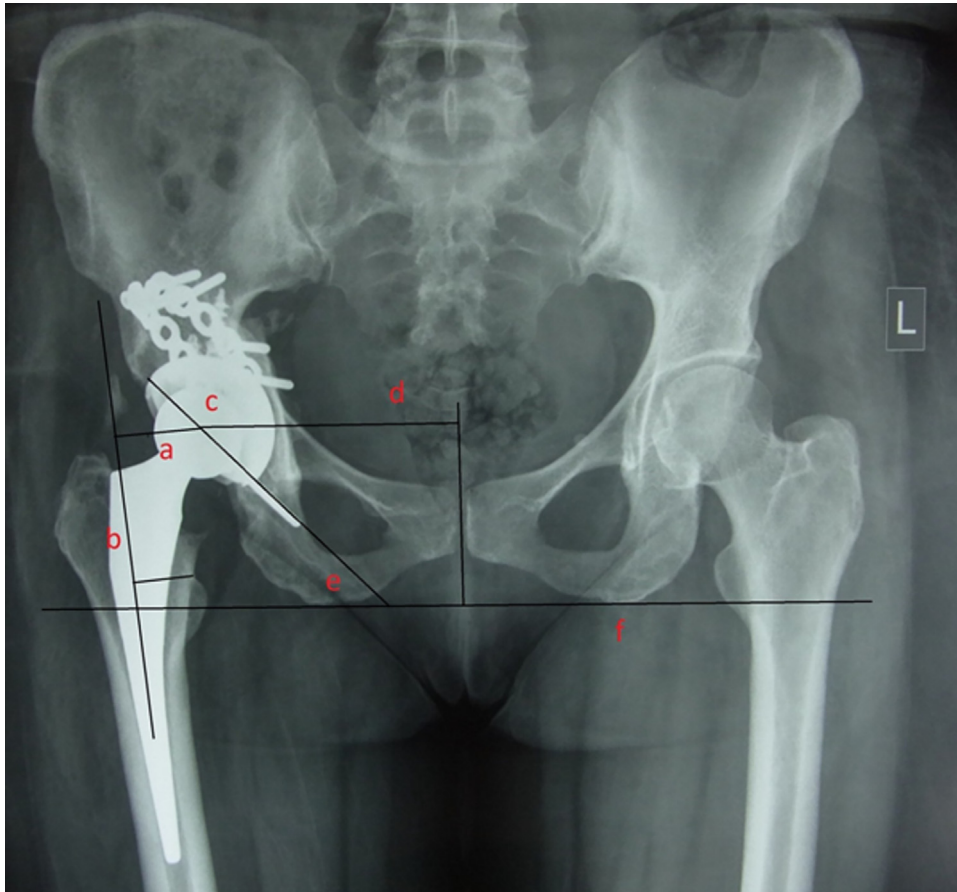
Sample radiograph showing lines drawn for estimation of radiological parameters. a –Horizontal offset, b –Vertical offset, c –Centre of rotation, d –Body lever arm, e –Angle of inclination, f –Trans-ischial line.
